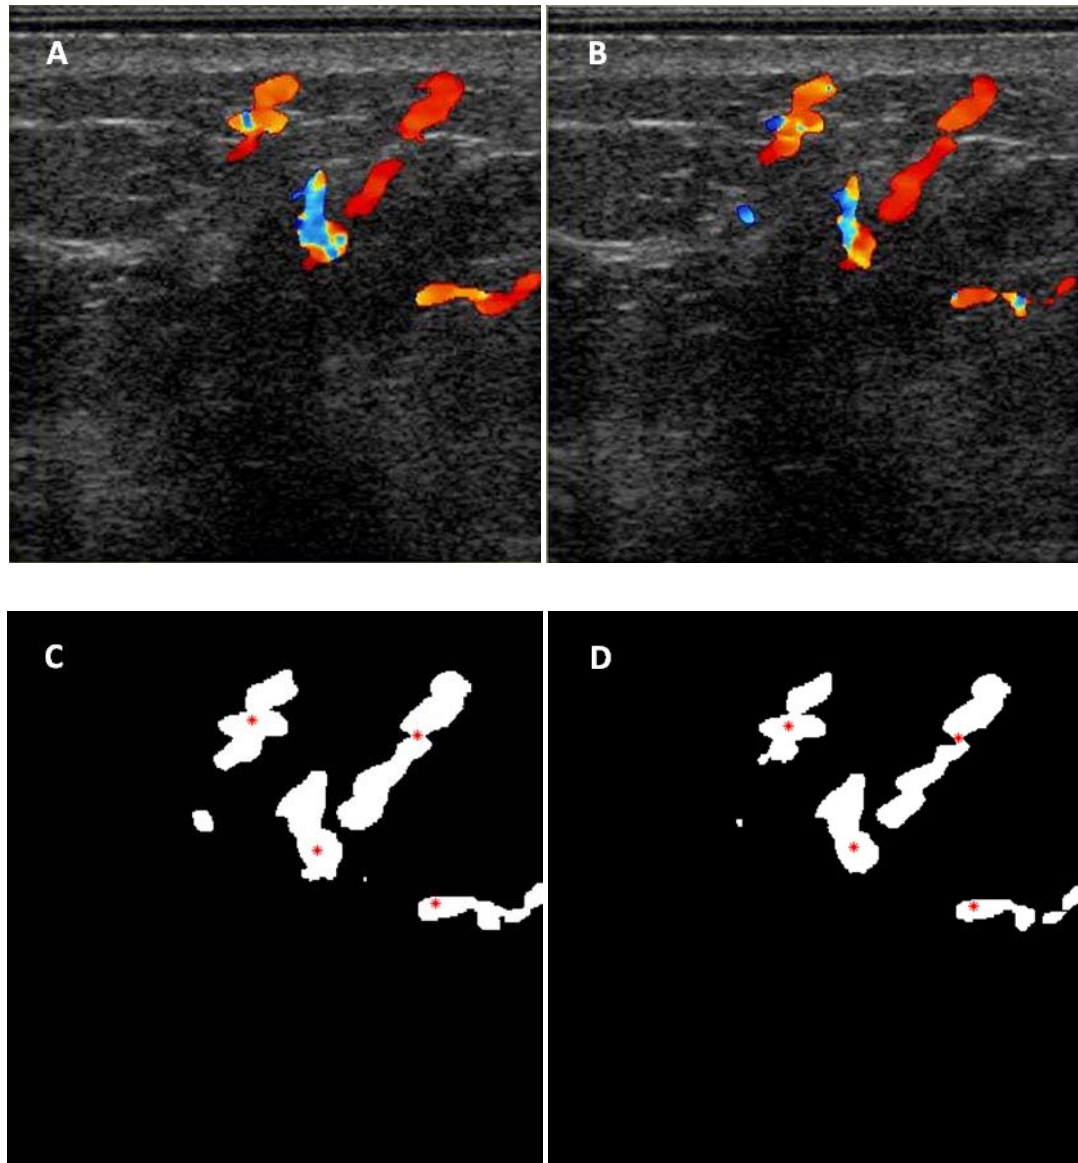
A patient with invasive ductal carcinoma showing hypo-echoic, irregular shaped mass on the left breast scanned before chemotherapy. A & B: Doppler image pair showing blood flow around the tumor scanned at equal breast compressions in the same session within 30 minutes. C & D: Registered DI-G image pairs of reference and homologous image volumes respectively. Radiologist identified Doppler fiducial (DF) points on twisting blood vessel segment are shown for reference as gray-colored stars. Separation between 17 of the DF pairs was 0.3 ± 0.3 mm compared with an MRE of 0.2 ± 0.2 mm from fiducials on the grayscale image volumes.
